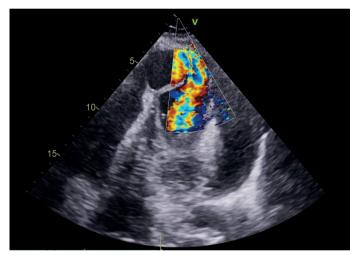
Modified apical 4 chambered view with colour Doppler demonstrating bidirectional shunt.
